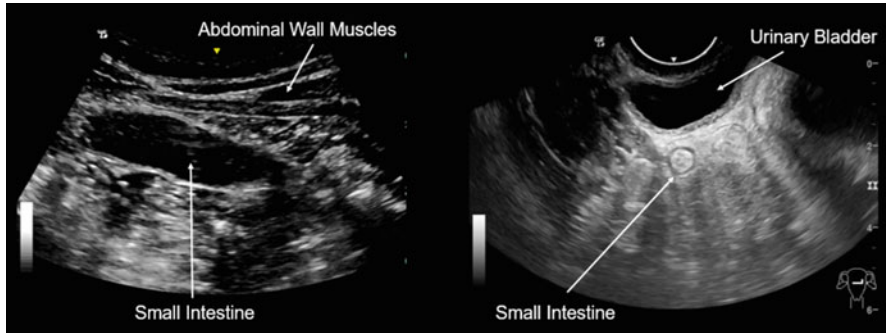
Ultrasound images of the small intestine. Ultrasound of the intestinal tract is being used more and more often in medical practice. The left panel is a transabdominal scan that shows a tubular structure with an anechoic (black) lumen. This is a fluid filled loop of small intestine. The right panel is a transvaginal pelvic scan that shows a circular structure with a hypoechoic (dark) rim and a hyperechoic (bright) center. This is a cross section through a loop of small intestine that is not fluid filled
